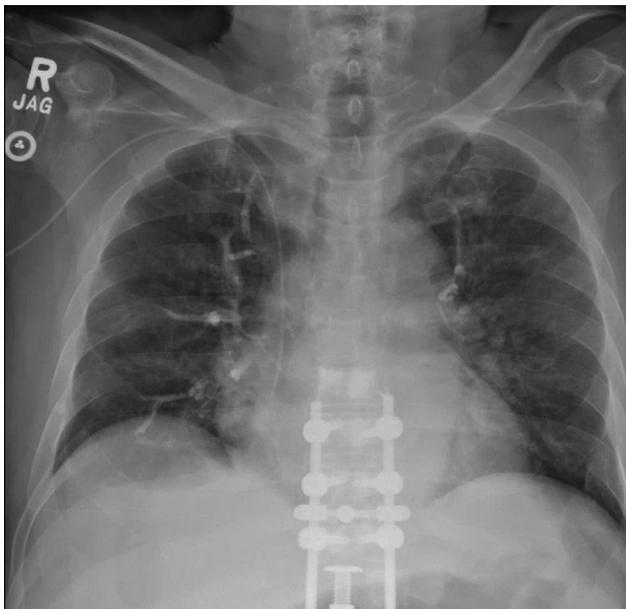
Post-operative chest radiograph obtained after a patient developed respiratory compromise following vertebral PMMA augmentation via cannulated pedicle screws. Bilateral cement emboli were noted, leading to further workup with a chest CT.
